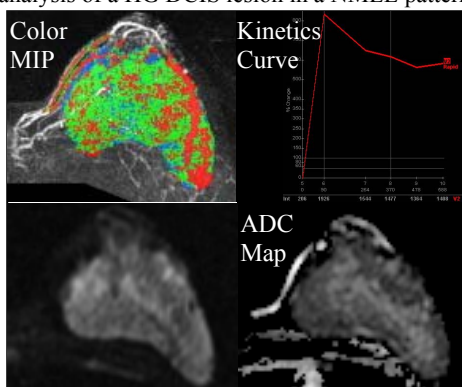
Appearance of a HG DCIS lesion involving the entire left breast on DCE MRI and DWI (maximum lesion size = 79 mm). Kinetics curve demonstrates rapid initial enhancement (PE = 834%). Cover overlay map on maximum intensity projection image (MIP) demonstrates mixed delayed kinetics with 16% washout. The lesion demonstrates high signal on DWI (CNR = 3.28) and ADC map confirms restricted diffusion (ADC = 1.08×10^{-3} mm²/s).
